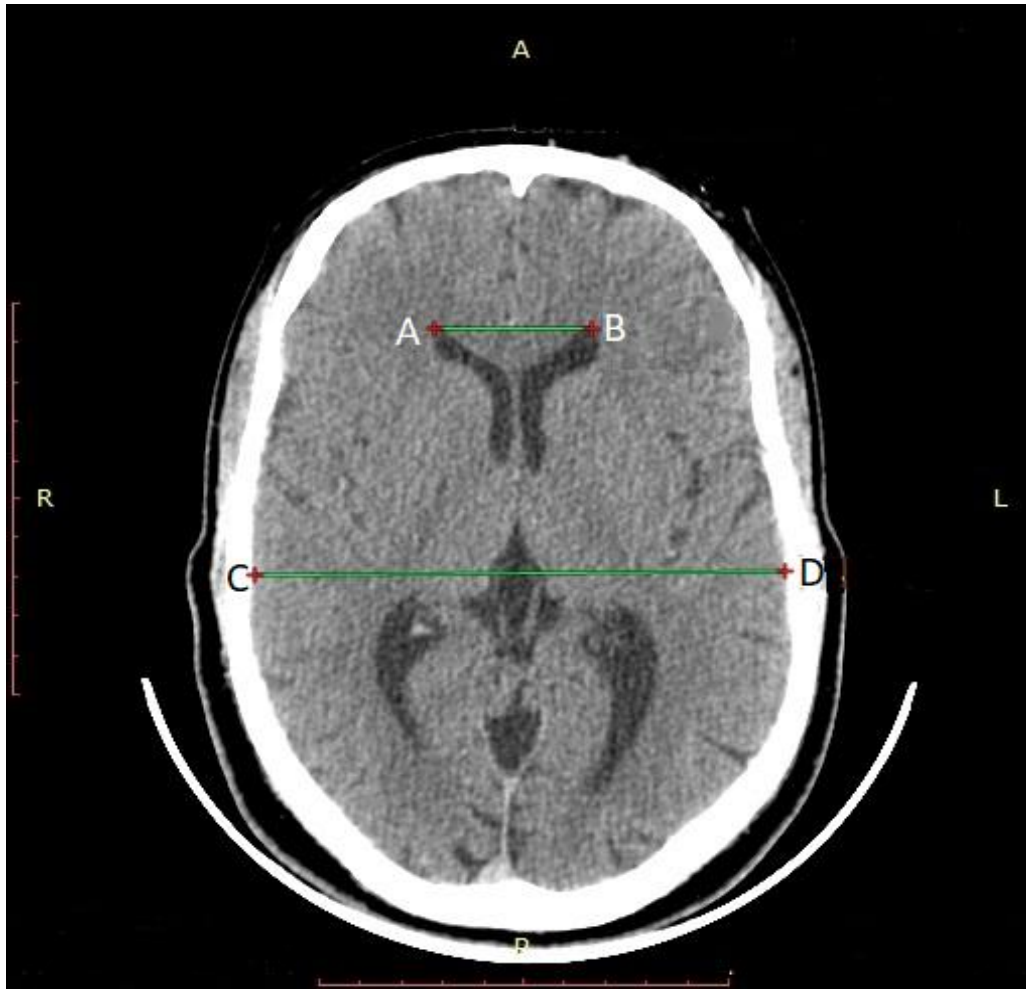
A CT image showing measurement Evan's index; determined by the ratio of the measured distance between the tips of the frontal horns (A-B) of lateral ventricles and the distance between the inner skull tables at the midpoint of the cranium (C-D), in axial plane.
